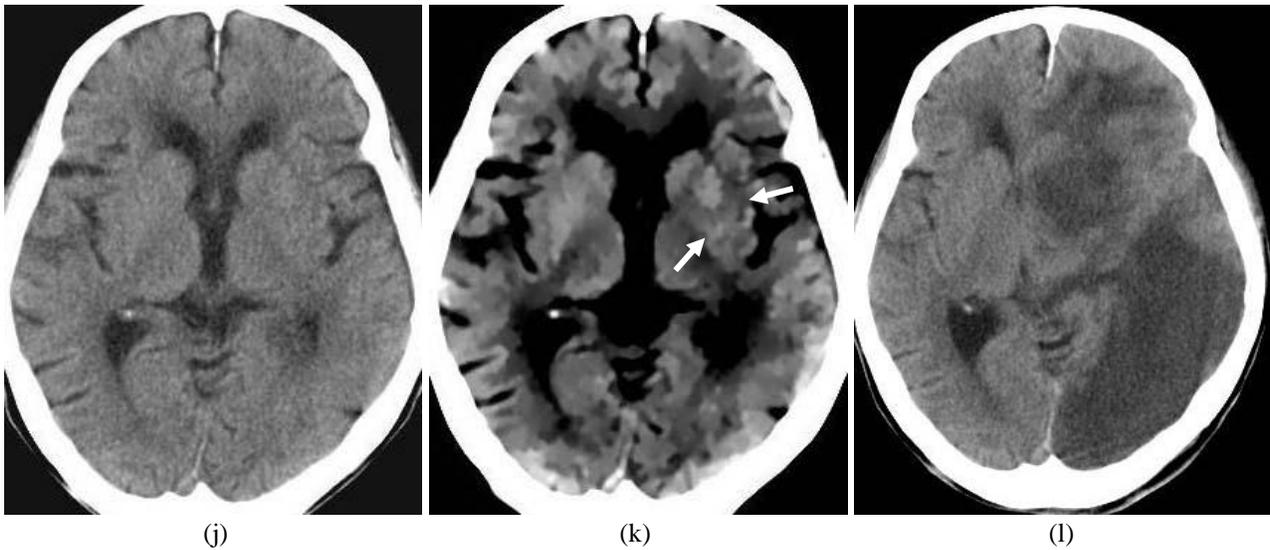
Non-enhanced CT images of four cases of acute ischemic stroke.
